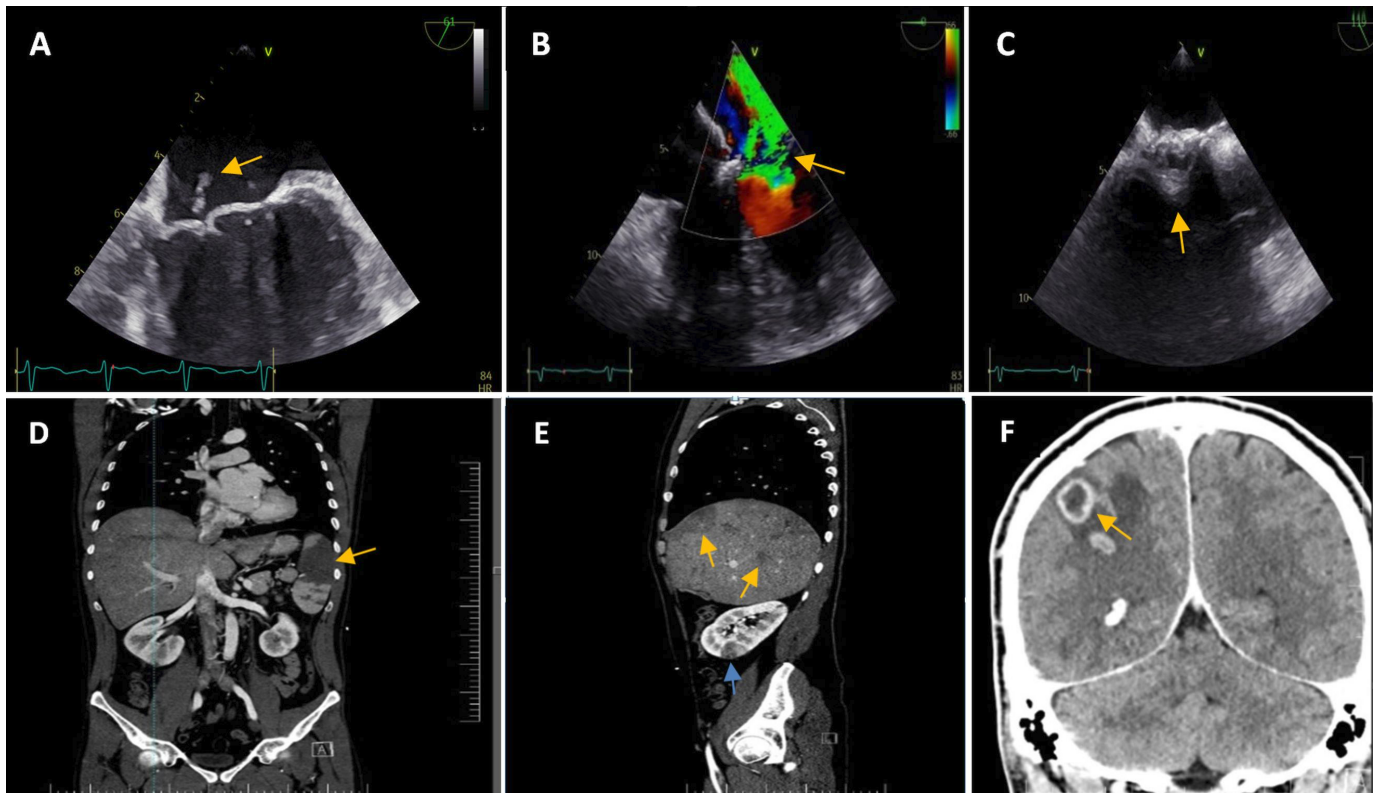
Infective endocarditis in a 40 years old patient with blood cultures positive for methicillin-sensitive *Staphylococcus aureus* and multiple systemic embolic abscesses (brain, splenic, liver): (A) vegetation at TEE imaging of the anterior mitral valve in the cleft area (arrow). (B) TEE colour Doppler—severe mitral regurgitation (arrow). (C) TEE abscess on the right side of the atrial surgical patch with echo lucent area (arrow). (D) CT—large splenic abscess (arrow) (E) CT—liver structure with multiple subcapsular peripheral areas, imprecisely delimited with low contrast uptake—budding abscesses (yellow arrows), renal abscess (blue arrow) (F) CT—brain abscesses—ring enhancing lesions with slightly perilesional oedema (arrow). TEE, transoesophageal echocardiography.
